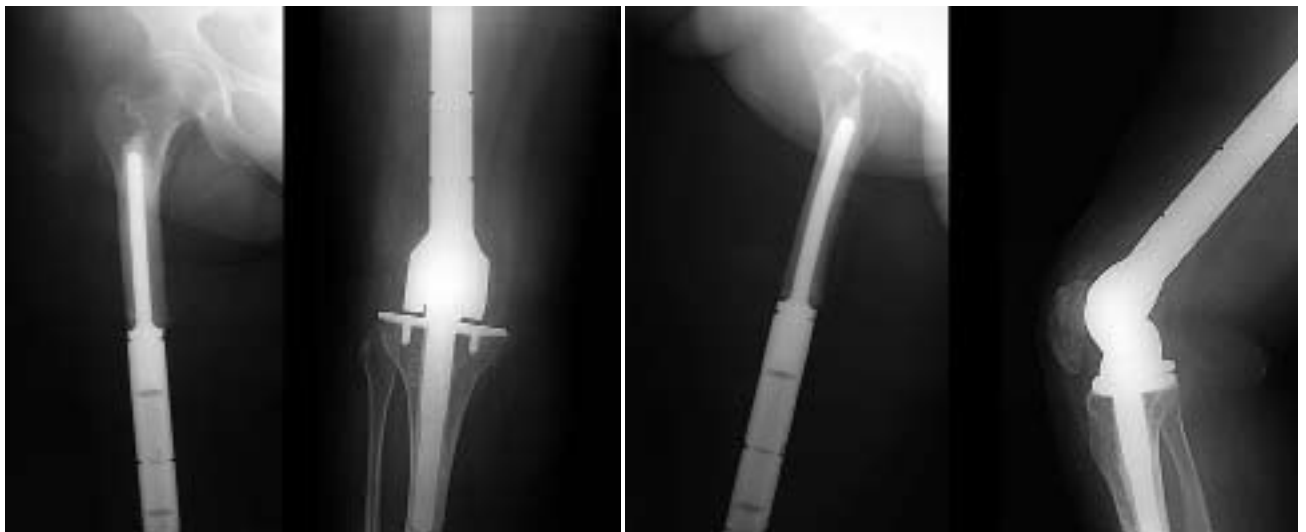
Radiographs of the same patient in Fig.1 showing reconstruction after tumor resection with cemented TMTS tumor resection prosthesis (postoperative 5 years). TMTS: Turkish Musculoskeletal Tumor Society.
